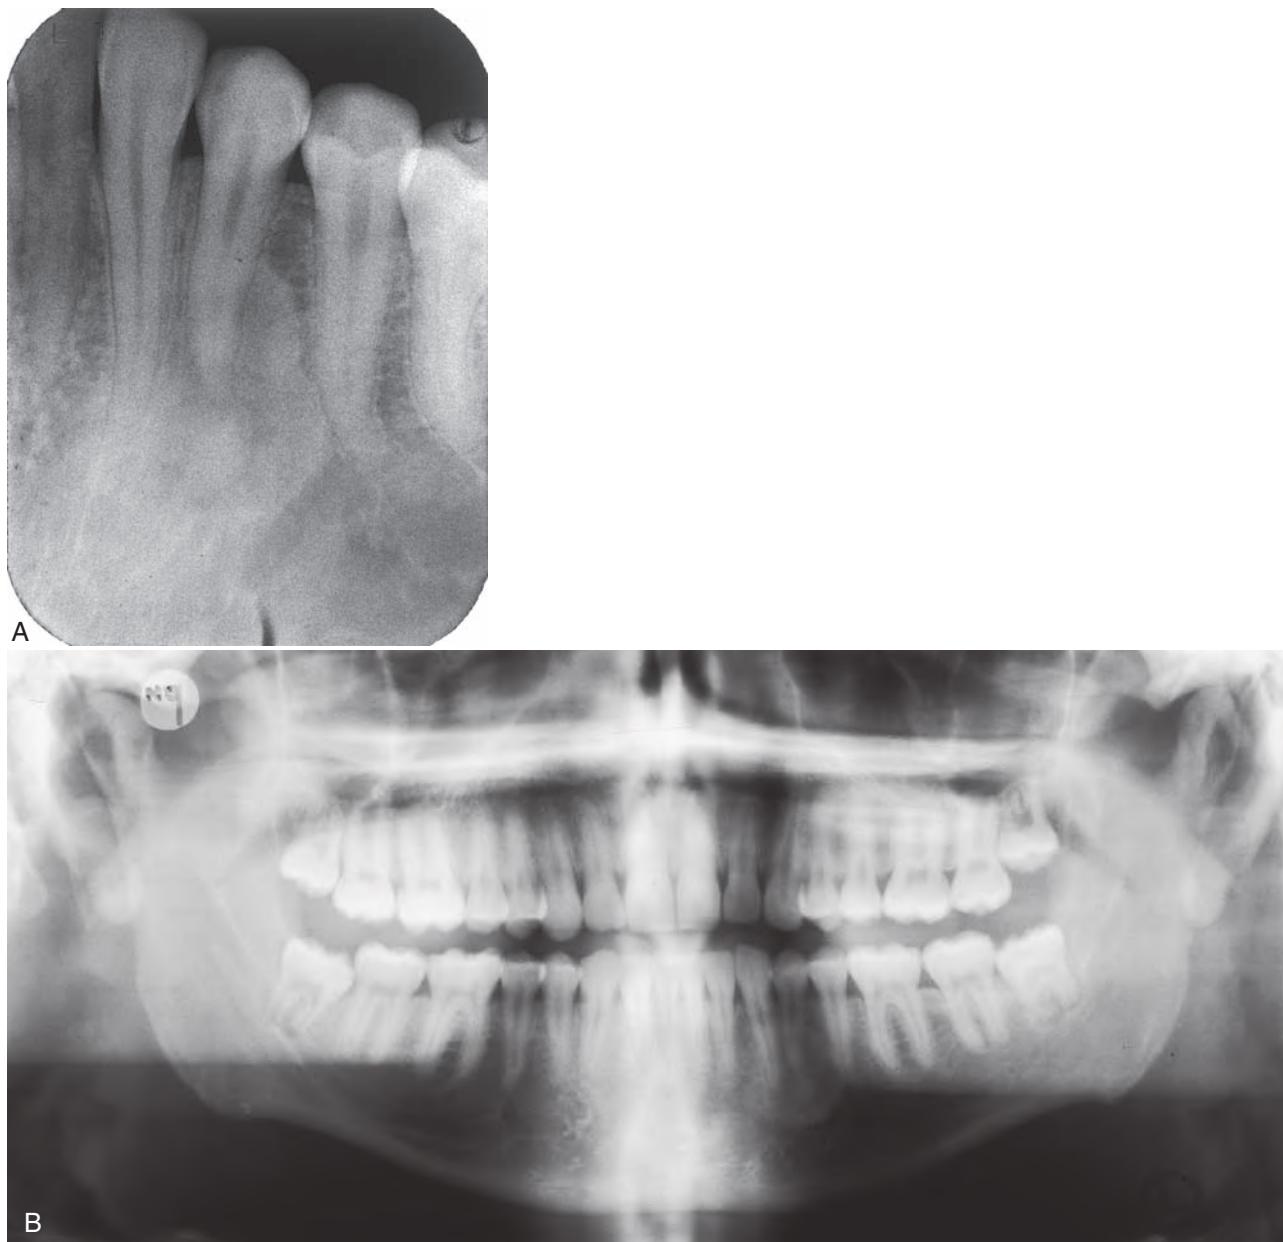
An 18-year-old patient with cemento-ossifying fibroma—an example of a condition that needs to be reevaluated at periodic visits. A, Periapical radiograph. B, Panoramic radiograph. (Courtesy S. Addison, Chapel Hill, N.C.)
